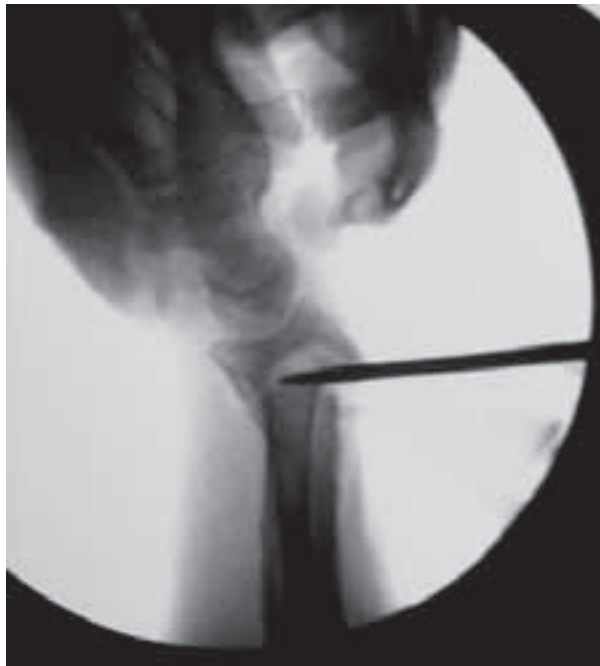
Intraoperative x-rays.
